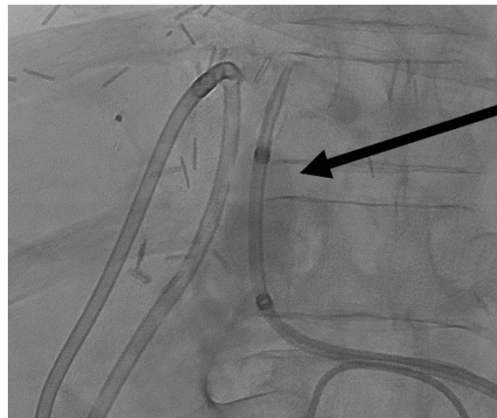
Frontal radiograph of drain injection performed through the left sided percutaneous biliary catheter demonstrating clot within the biliary system (black arrow).
